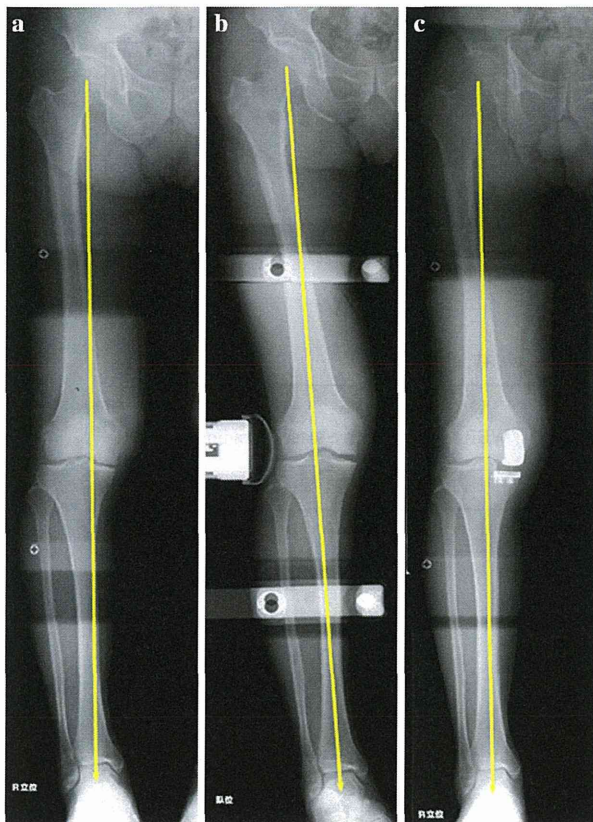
a A full-length preoperative standing radiograph of an osteonecrosis patient. The arrow indicates the mechanical axis. b A preoperative valgus stress radiograph obtained in the supine position. A valgus force was applied at 150-N by a Telos arthrometer. c A postoperative standing radiograph obtained after medial UKA. The mechanical axis was slightly shifted medially from that observed on the valgus stress radiograph and passed slightly medially to the center of the knee
